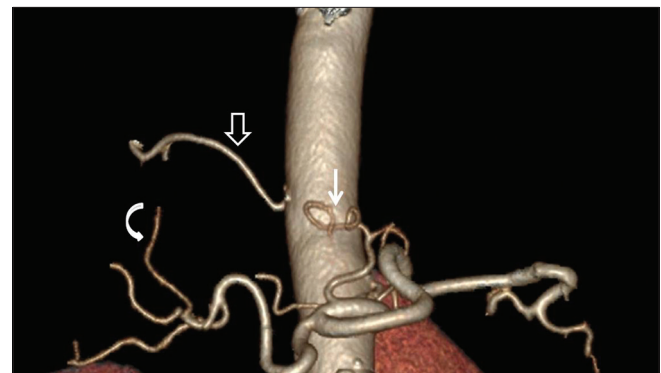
Three-dimensional volume-rendered image of a 69-year-old woman who underwent computed tomography angiogram of the abdomen for mesenteric ischemia showing supply from the right hepatic artery to segment 4 of the liver. Curved arrow – branch from the right hepatic artery, solid arrow – incidental replaced left hepatic artery, and open arrow – phrenic artery.
